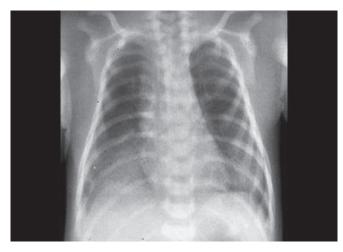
Chest X-ray showing infiltrates in right lower lung which is asymmetrical bilaterally with history of prolonged rupture of membrane, suggesting congenital pneumonia. In developing countries, pneumonias account for more than 50% cases of respiratory distress in newborn. In congenital pneumonia, respiratory distress is noticed soon after birth or during first 24 hours. Auscultatory signs may be nonspecific. The newborn may die from pneumonia without manifesting distress. Neonates may develop pneumonia postnatally as a consequence of septicemia, aspiration of feeds, and ventilation for respiratory failure.
